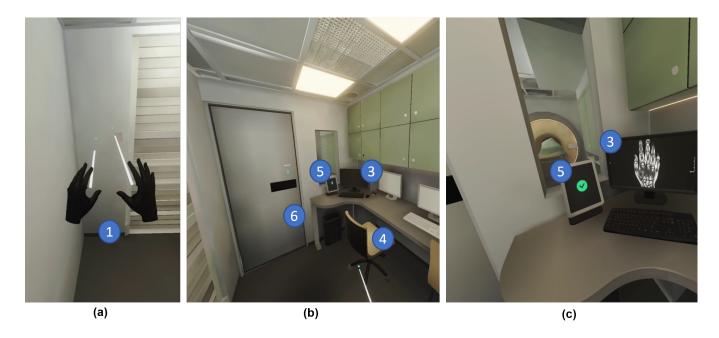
All the interactive elements of our system are confided in the mobile MRI control room. The doors and the tablet are marked with bouncing arrows and textual labels. The 3D chair model denotes the position of a physical chair in the real world, tagged with the wrist tracker.
